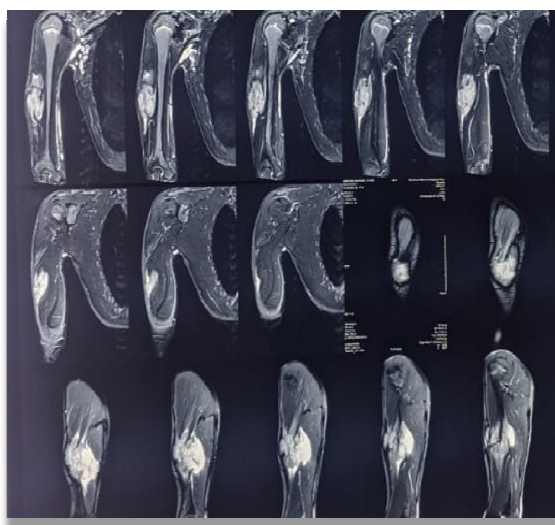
MRI of right arm
